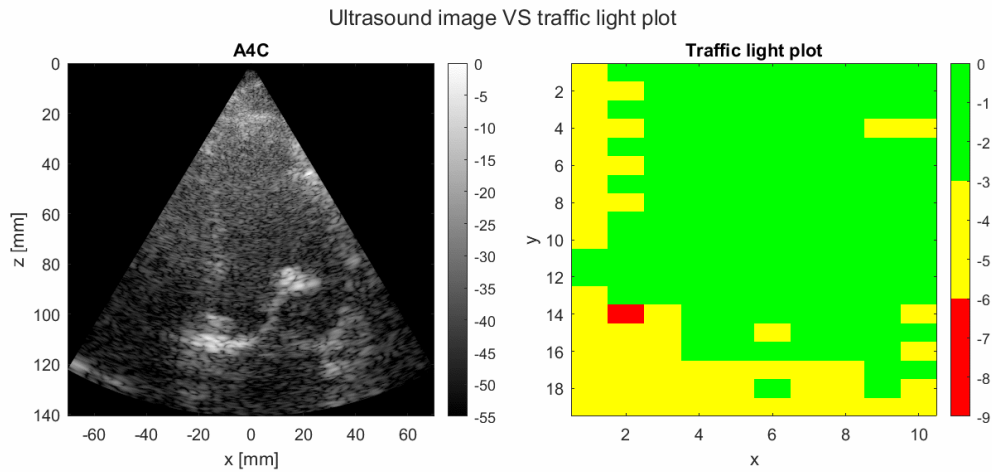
An example of a subplot figure of one frame of the ultrasound recording and the traffic light plot for case (c).
